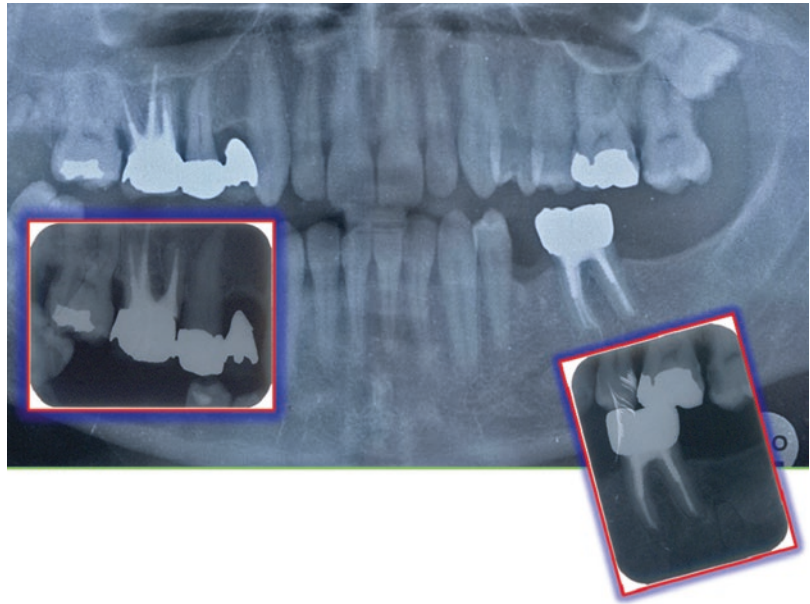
On left the ante-mortem radiograph of a missing person with a severe bone resorption and a cavity on the second molar; on the right a post-mortem image of an unknown body showing the same bone resorption pattern
